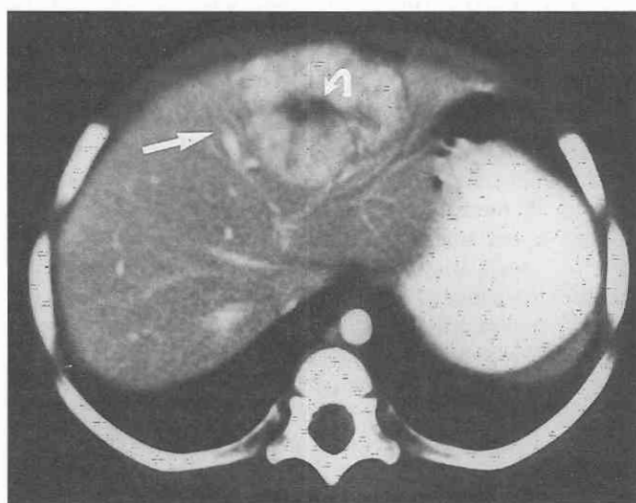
Focal nodular hyperplasia. CT of the liver obtained during the early arterial phase of intravenous contrast administration reveals an enhancing mass in the left lobe of the liver (arrows) with a visible central scar of low attenuation (curved arrow).
